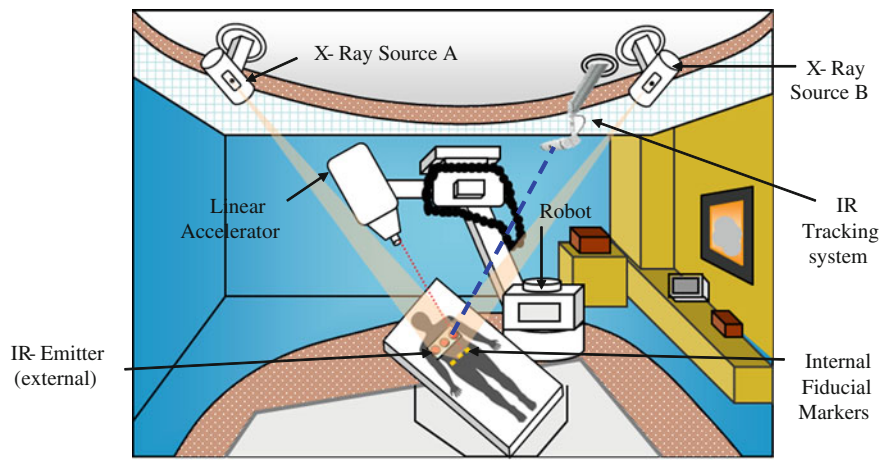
CyberKnife system. X-ray source with low energy is used to detect soft tissue tumors or implanted fiducial markers during the treatment. IR tracking system synchronized with the tumor motion can reduce safety margins for respiratory gating or breath-hold techniques [46, 53]
